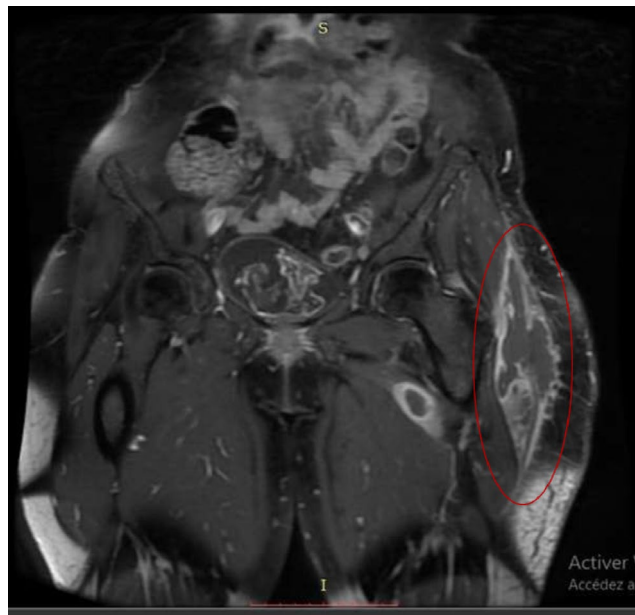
MRI image of pelvic and bilateral femur showing extension of the abscess distally around the left greater trochanter
